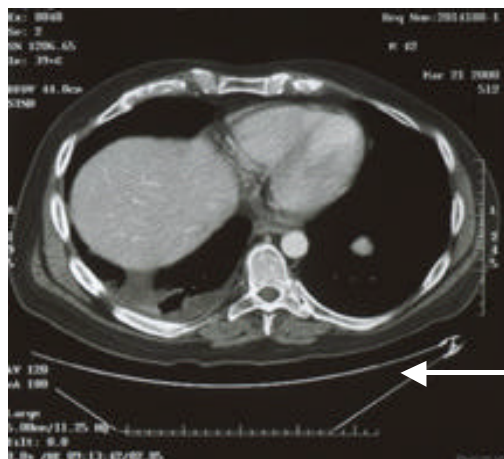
Computed tomographic scan of the chest demonstrating a 2 cm lesion in the lower lobe of the left lung
